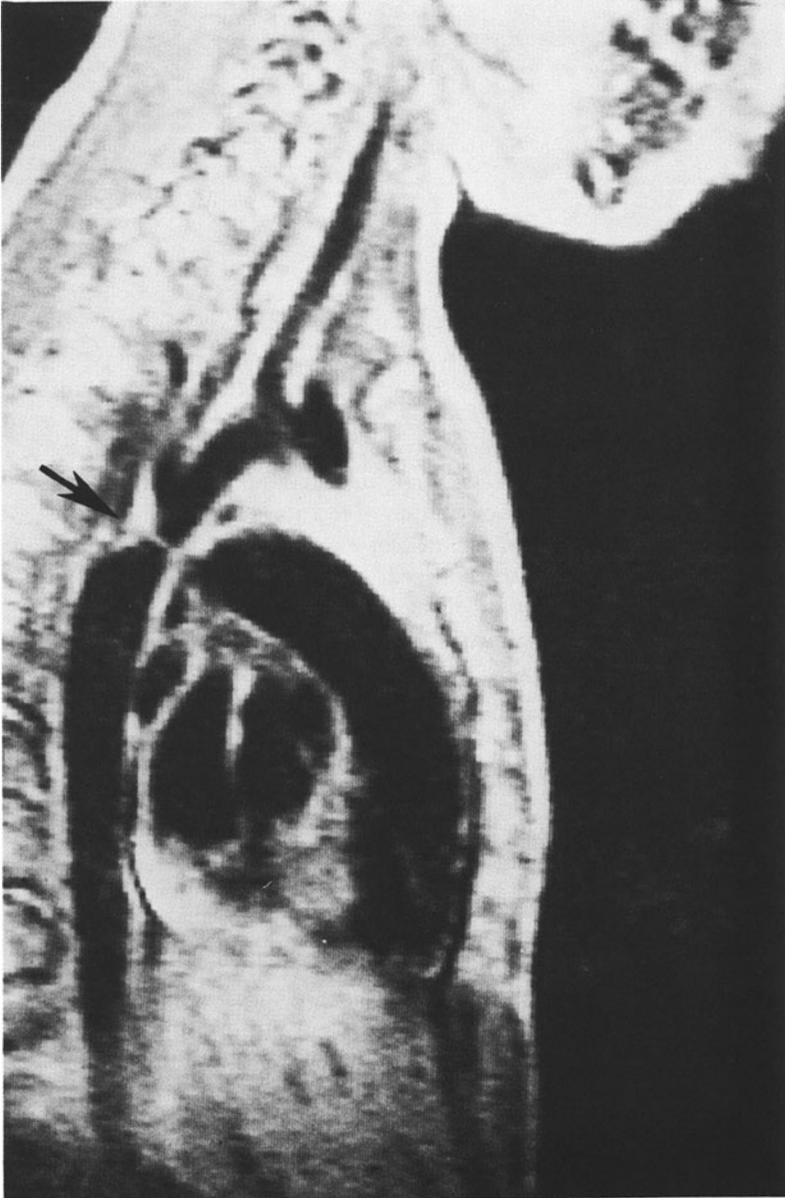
Sagittal MRI section revealing a discrete coarctation of the aorta with a posterior shelf (arrow). Post stenotic dilatation of the aorta is noted.
